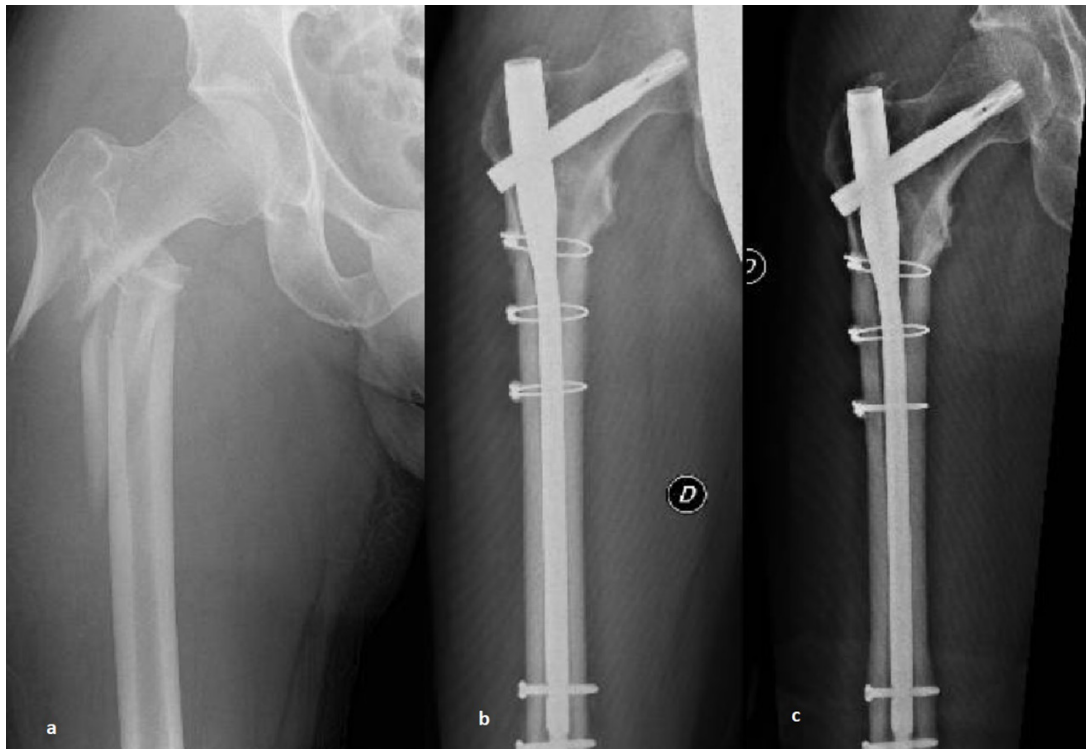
Exemplificative case of subtrochanteric fracture treated with ORIF and 3 cerclages: a, preoperative x-rays; b, postoperative x-rays; c, bone callus and healing of fracture at 3 months follow-up.
